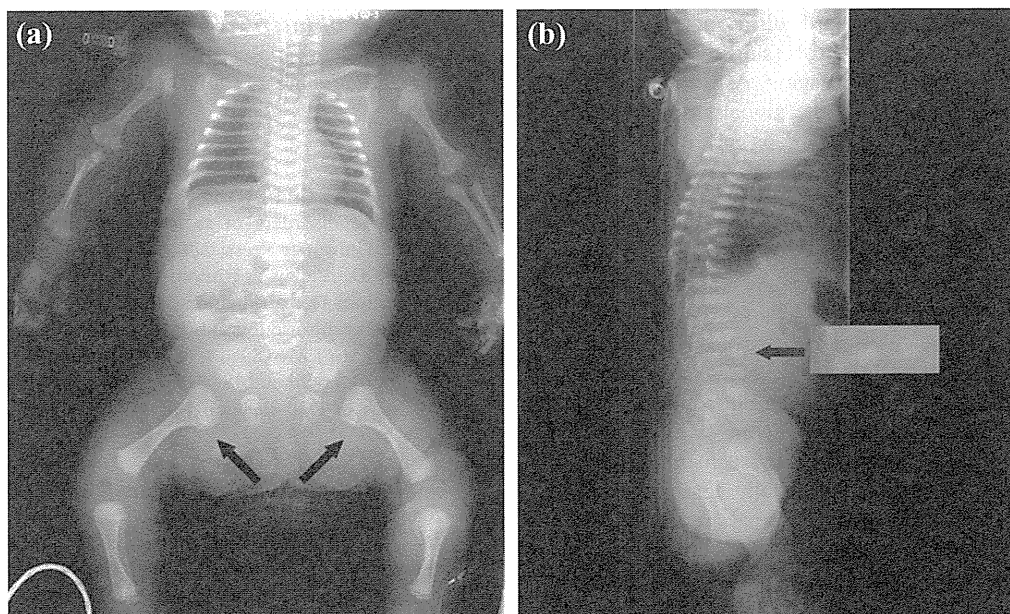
Standard radiographs after birth. (a) Frontal image showing relative broad thorax, platyspondyly, shortness of the limbs, short femora and dumbbell appearance (an arrow) of tubular bones, and broad ilia with hypoplasia of basilar portion (trefoil-shaped pelvis). (b) Lateral image showing prominent splaying of metaphyses of femora, coronal cleft in the 4th lumbar vertebral body (an arrow). Magnification of the coronal cleft is shown to the right of the arrow.
